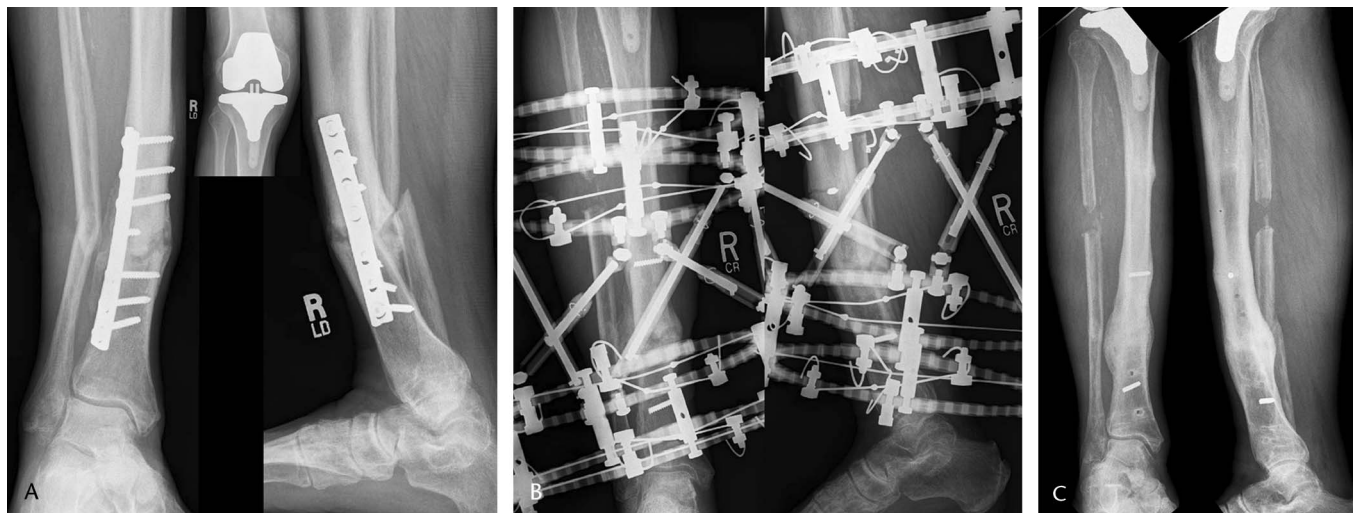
A, Presenting anteroposterior and lateral radiographs of a 70-year-old man (patient 13) with type 1 diabetes mellitus and hypertension who was referred at 10 months following a closed distal tibial shaft fracture treated at an outside facility with plate and screw fixation and bone grafting. The radiographs demonstrate a nonunion with deformity. The patient had a recent history of recurrent cellulitis, but no history of purulent drainage from his incision. Preoperative nuclear medicine evaluation was suspicious for infection. Deep cultures at the time of plate removal, local debridement, and bone grafting were positive for *Staphylococcus aureus*, making this an active, nondraining infection. This case was further complicated by the fact that the patient had a pre-existing ipsilateral total knee arthroplasty. B, Radiographs 2 months following application of the Taylor Spatial Frame show correction of the deformity and compression being applied (note bending of the wires). C, Final radiographic result at 50 months following application of the Ilizarov external fixator and 43 months following removal of the Taylor Spatial Frame (total time in Taylor Spatial Frame was 7 months) shows anatomic alignment with solid bony union and retention of the total knee arthroplasty without clinical evidence of infection.
